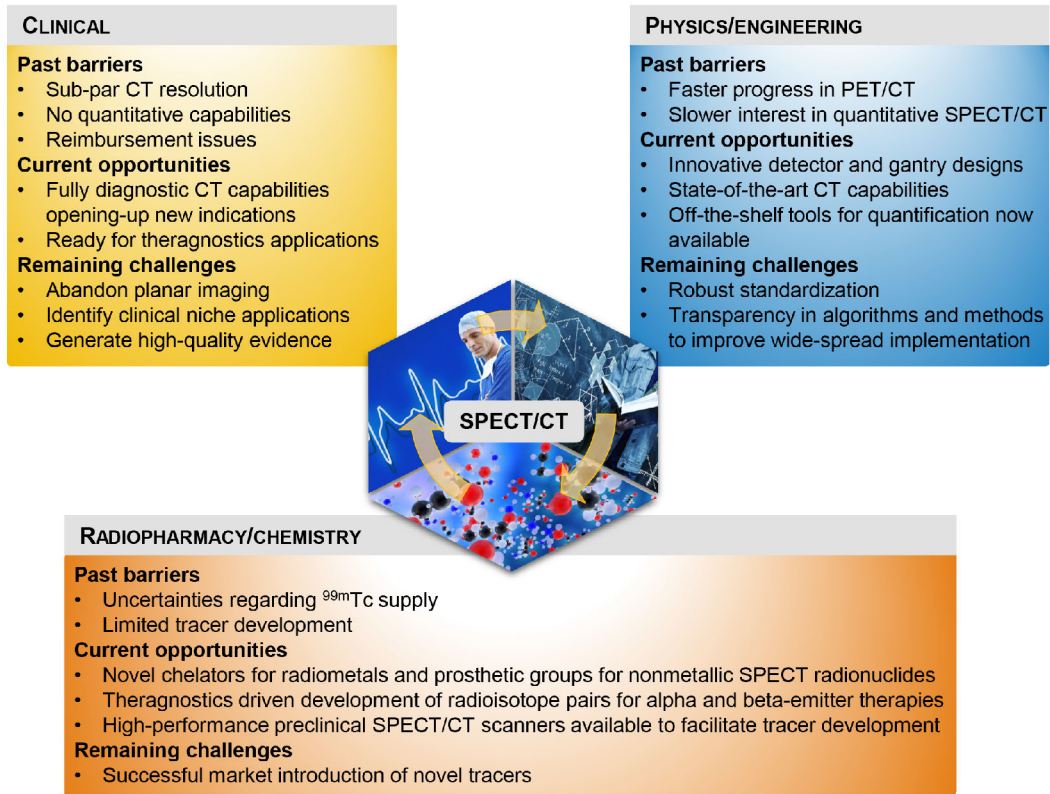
Summary of past barriers, current opportunities, and remaining challenges in developing the SPECT/CT ecosystem, covering the clinical, physics/engineering, and radiopharmacy/chemistry fields.
